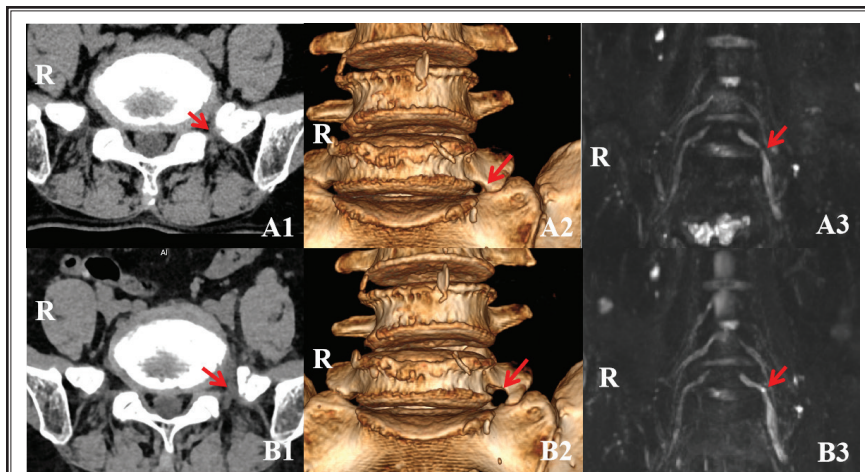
A1: preoperative axial CT images of the lumbar spine, respectively. B1: postoperative axial CT images of the lumbar spine, respectively. The red arrow in A1 indicates the pseudoarthrosis site preoperatively, while the red arrow in B1 shows the significantly enlarged bony gap after the pseudoarthrosis was removed. A2: Preoperative 3D reconstructed CT frontal view of the lumbar spine for Case 2. B2: Postoperative 3D reconstructed CT frontal view of the lumbar spine for Case 2. The red arrow indicates the significantly increased gap between the L5 transverse process and the sacral ala after the pseudoarthrosis removal. A3: Preoperative magnetic resonance neurography of the lumbosacral plexus for Case 2, with the red arrow indicating the compression point on the left L5 nerve root, showing an interruption in nerve continuity. B3: Postoperative magnetic resonance neurography of the lumbosacral plexus for Case 2, with the red arrow indicating the restored continuity of the left L5 nerve root, with minor local tissue edema.
